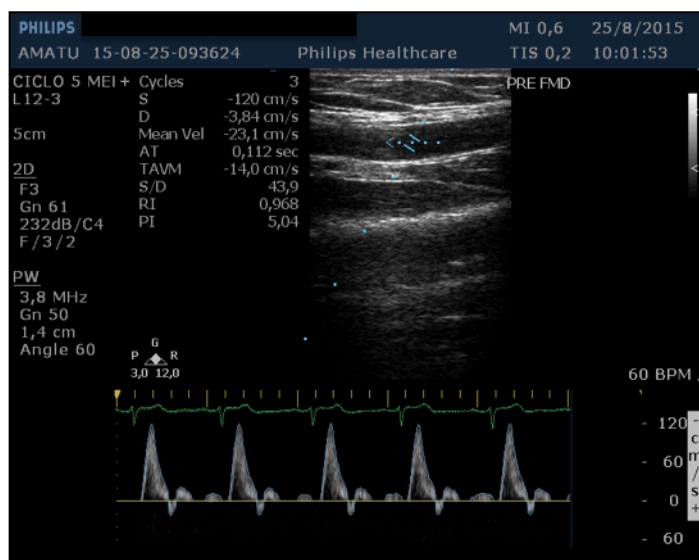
Exemplo de análise de doppler.
